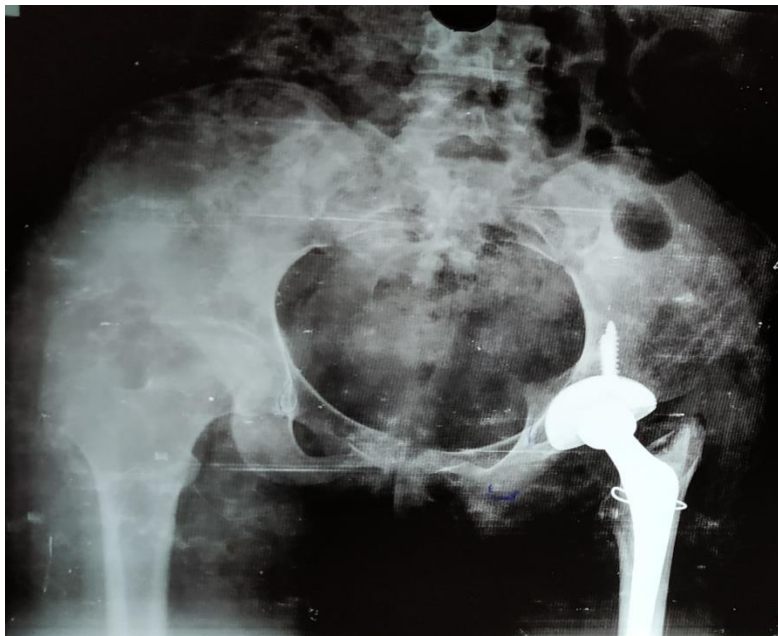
Post-operative pelvic X-Ray of the patient after total hip replacement.
